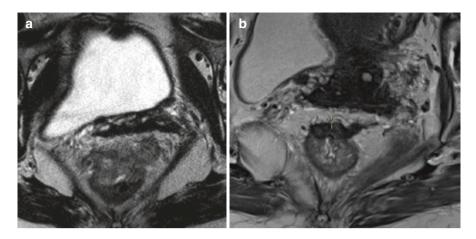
(a) A pretreatment MRI demonstrates a locally advanced T3d low rectal tumour which infiltrates the rectal wall at 11-2 o'clock with evidence of contiguous EMVI involving the middle rectal veins. (b) A post CRT MRI of the same patient shows evidence of fibrotic changes within the treated scan, however the intermediate signal predominates within the intra and extraluminal components suggesting residual disease – TRG4
